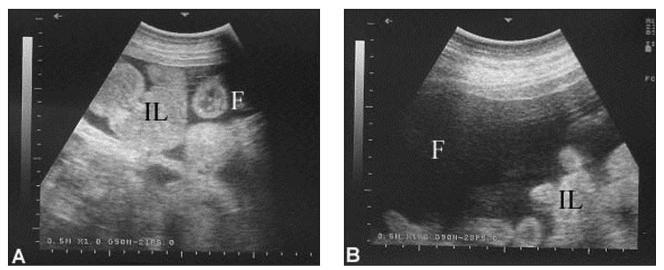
Cross-sectional ultrasonograms of intestines in 2 camels with trypanosomiasis. The intestinal loops (IL) appeared hyperechogenic and were surrounded by anechoic fluid (F).
